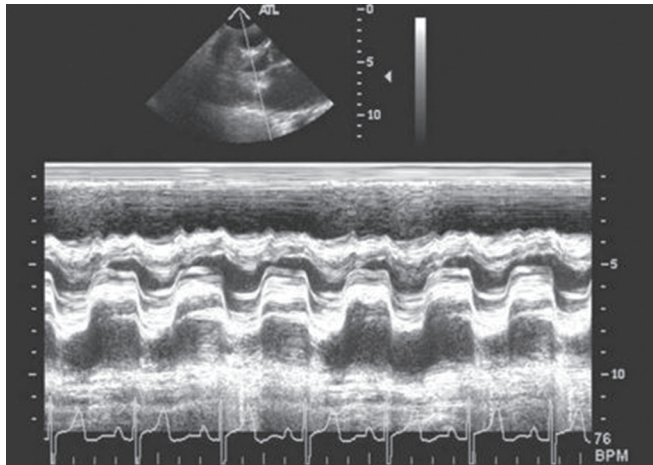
Echocardiogram showing thickened leaflets and anterior motion of posterior mitral leaflet in diastole, which is the diagnostic hallmark. EF slope (which directly correlates to the rate of transvalvular blood flow) is flat indicating severe stenosis
